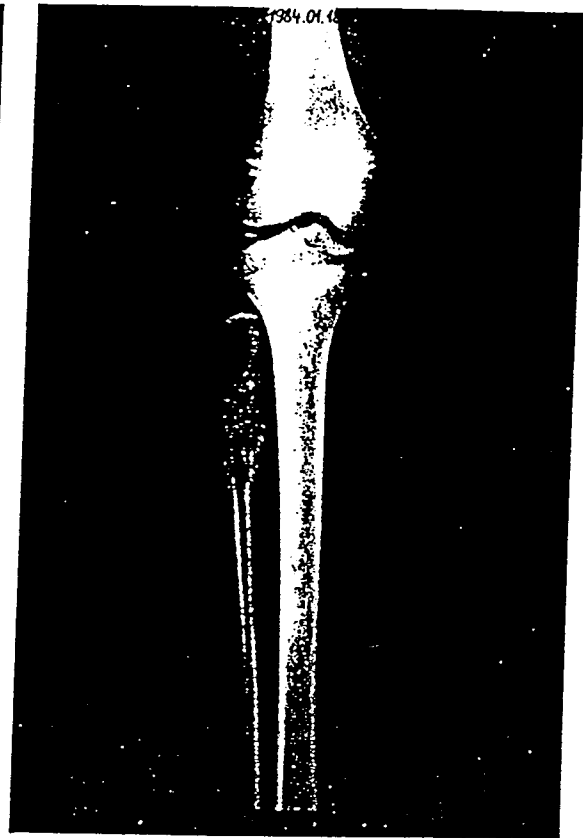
X-ray (18 Jan. 1984) three days prior to beginning of Ukrain therapy.
